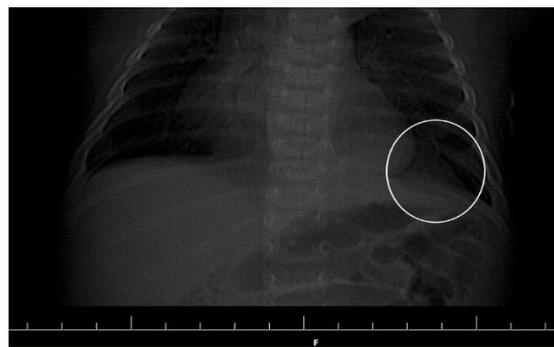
Chest X-ray. Triangular opacity on the base of the left lung
